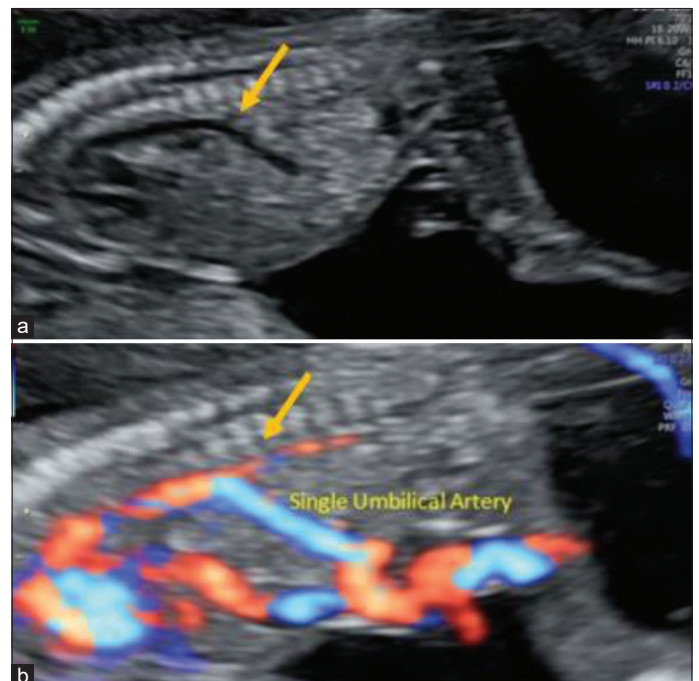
(a and b) images of second trimester scan (16–17 weeks). On follow-up, ultrasound done at 16 weeks, on B mode and color Doppler imaging in sagittal view. Arrows showing an abrupt narrowing of the aorta in the region of the mid abdomen distal to the origin of the umbilical artery
